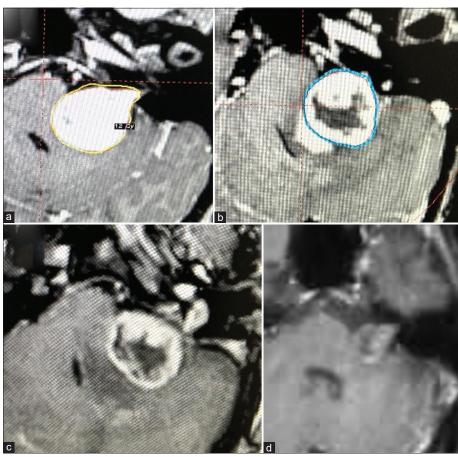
(a) At time of GKRS (volume 3.2 cc); (b) MRI at 8 months showing central necrosis with pseudoprogression of the tumor (volume 4.1 cc) with no clinical deterioration; (c) spontaneous regression of pseudoprogression with reduction in the size of the tumor at 12 months MRI (volume 2.9 cc); (d) significant volumetric reduction of the tumor at 32 months MRI (volume 1.9 cc)
